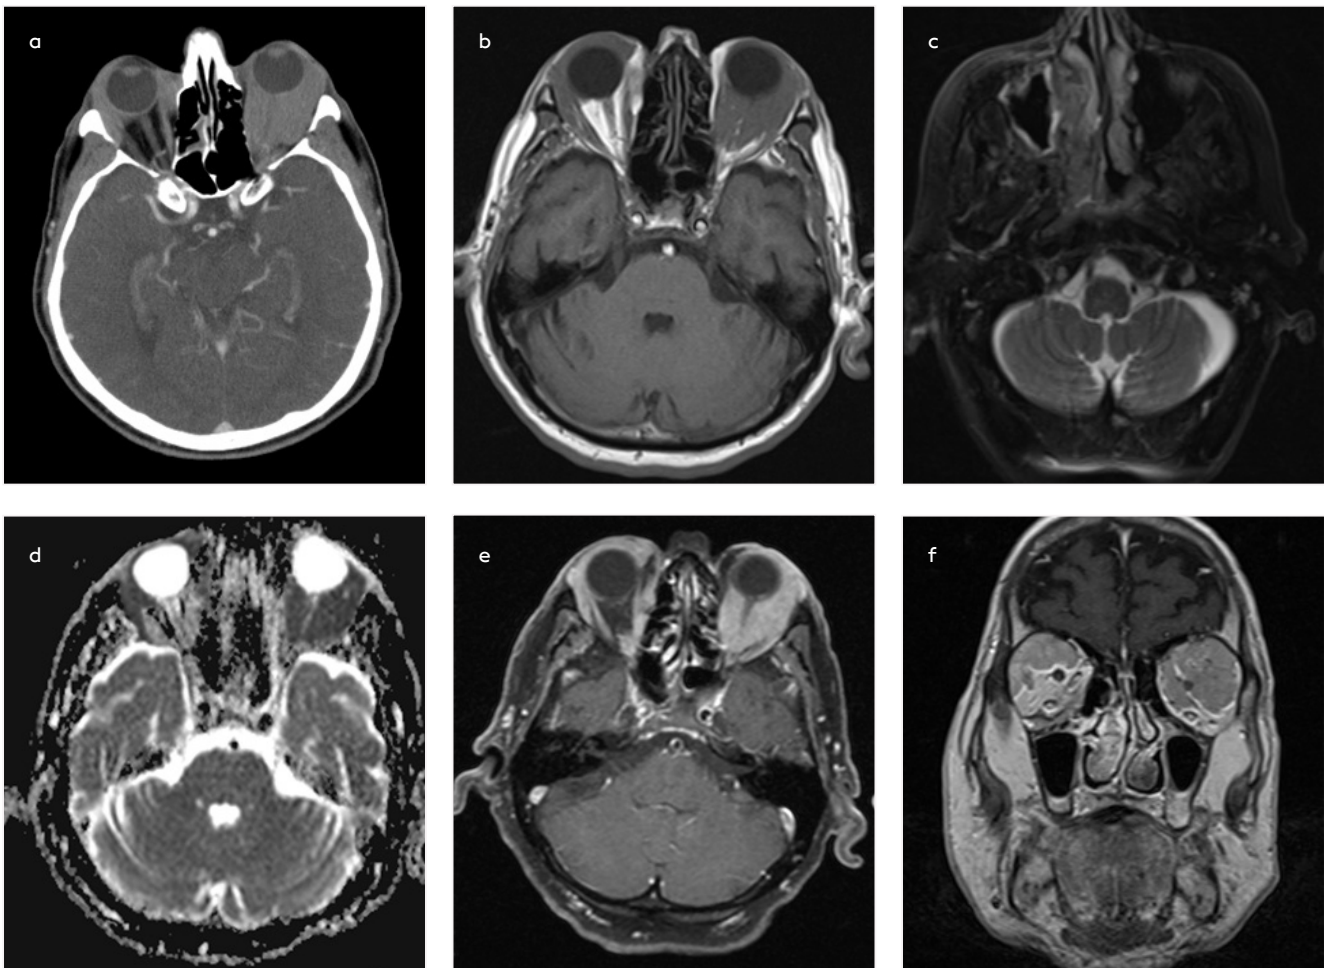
a-f. A 79-year-old male patient with primary EHNL (NHL, Marginal zone lymphoma, stage IE) in bilateral orbital space, received chemotherapy and disease free more than 2 years. Contrast-enhanced axial (a) CT image shows a well-defined, regular shaped soft tissue masses involving the bilateral orbital extraconal area. The mass lesions show hypointense on axial T1WI (b), isointense on axial fat-suppressed T2WI (c), restricted diffusion on DWI (d) and markedly homogeneous enhancement on axial (e) and coronal (f) contrast-enhanced T1WI.
